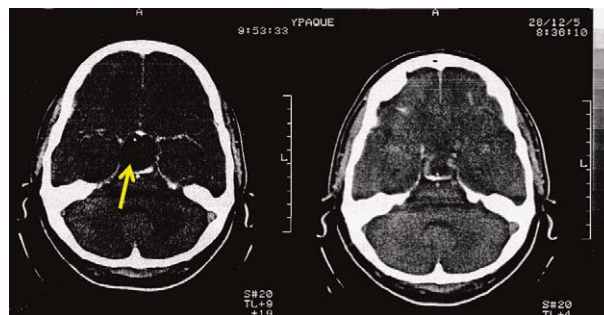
Skull computed tomography scan before (left side) and after (right side) neurosurgical procedure. The arrow points to the hypodense oval cystic tumor (initially a suspected cyst with a measured diameter of about 2.7 cm) in the sellar and suprasellar area.
